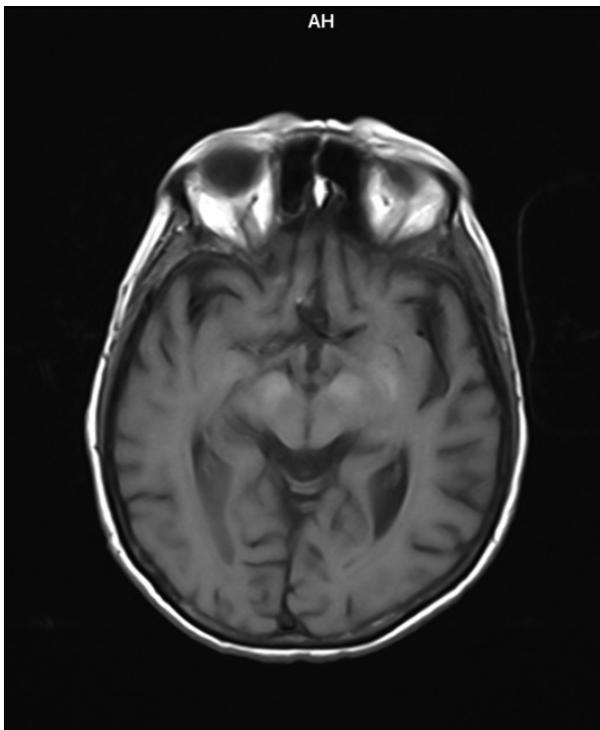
Axial MRI T1-weighted image shows symmetrical hyperintense signal changes in bilateral midbrain in the region of the substantia nigra.
